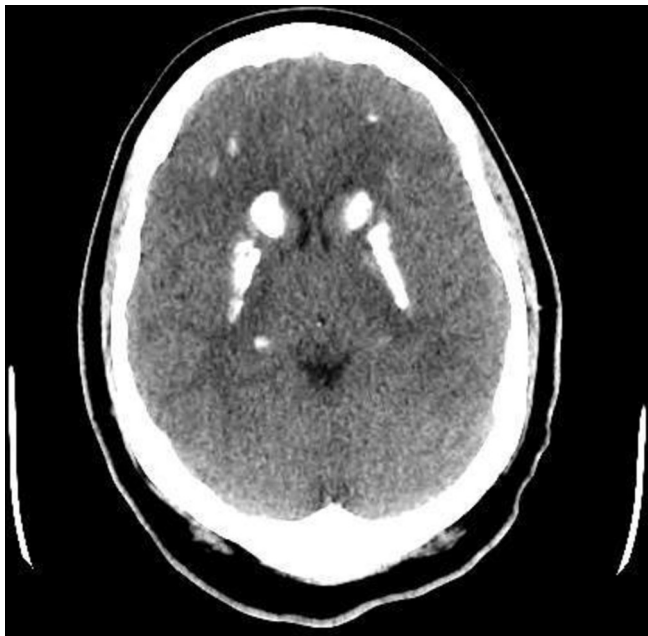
CT of brain showing extensive basal ganglia calcifications.
